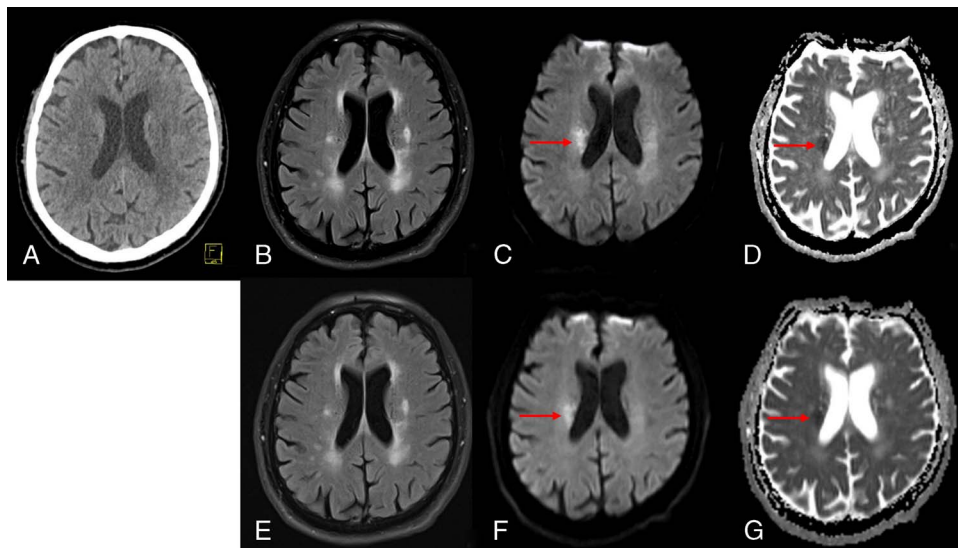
CT-occult acute ischemia (right corona radiata). Axial noncontrast head CT (A), fluid-attenuated inversion recovery (FLAIR) (B and E), diffusion-weighted imaging (DWI) (C, F), ADC-map (D and G) from the standard-length protocol (top row) and ultrafast-MRI (bottom row) in a 72-year-old man presenting with acute left facial paralysis, dysarthria, and left-body coordination disorder. The noncontrast head CT showed no evidence of ischemia or hemorrhage. Magnetic resonance images showed acute focal infarction in the right internal capsule and the corona radiata (arrow). The images show the comparable quality and lesion conspicuity in the ultrafast protocol, compared with the conventional protocol.
